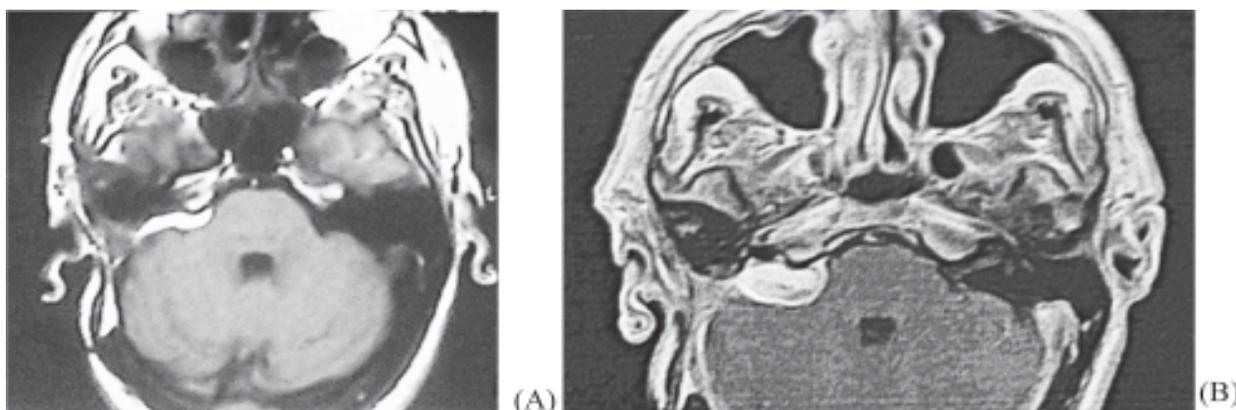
Follow-up MRI in 2005 (A) shows no evidence of residual or recurrence of VS after ETLA. Follow-up MRI in 2014
